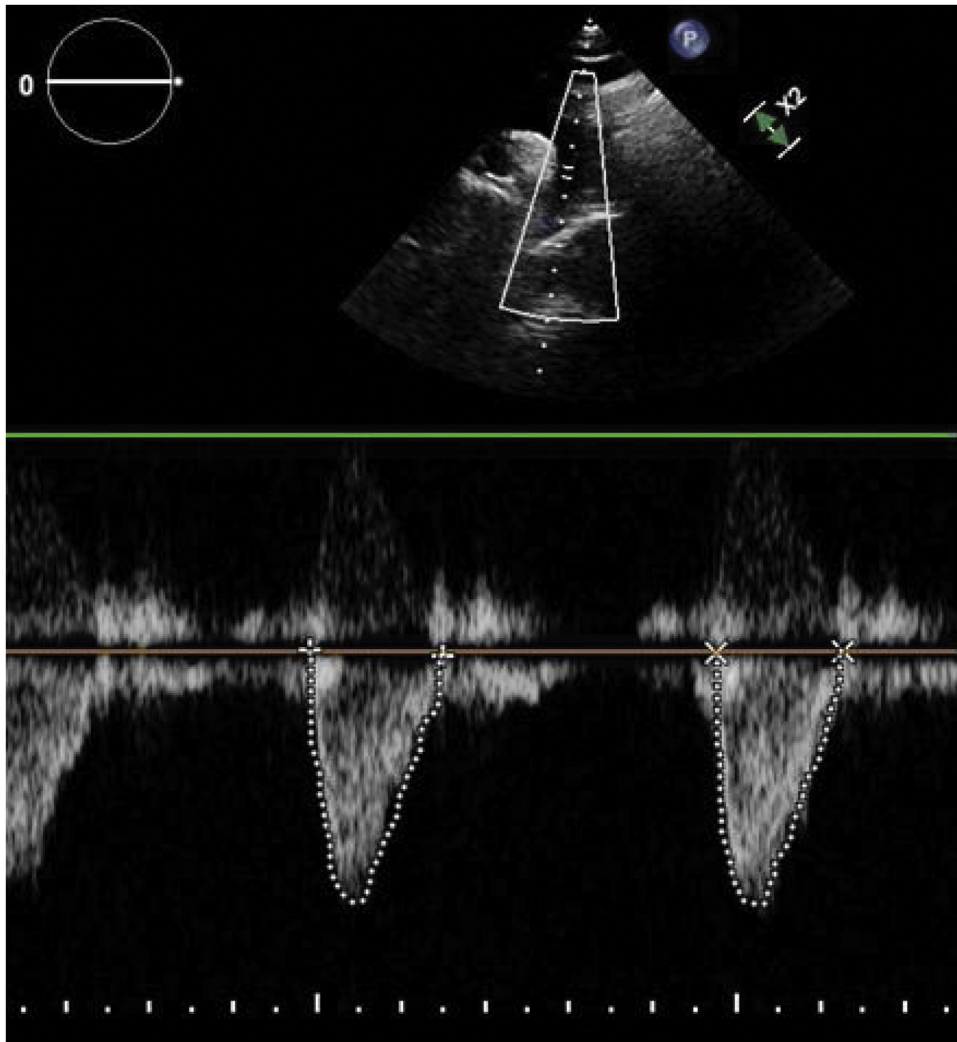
Echocardiographic image with the suprasternal window captured by an inexperienced operator. Measurements obtained from VTI after proper alignment.
